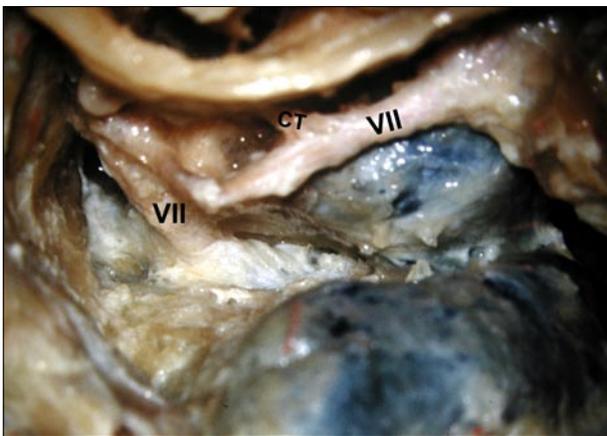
Removal of the labyrinth, incus, malleus and stapes via a right transpetrosal approach may enable the mobilization of the labyrinthine segment with distal part of the facial nerve (VII). (CT: chorda tympani)
